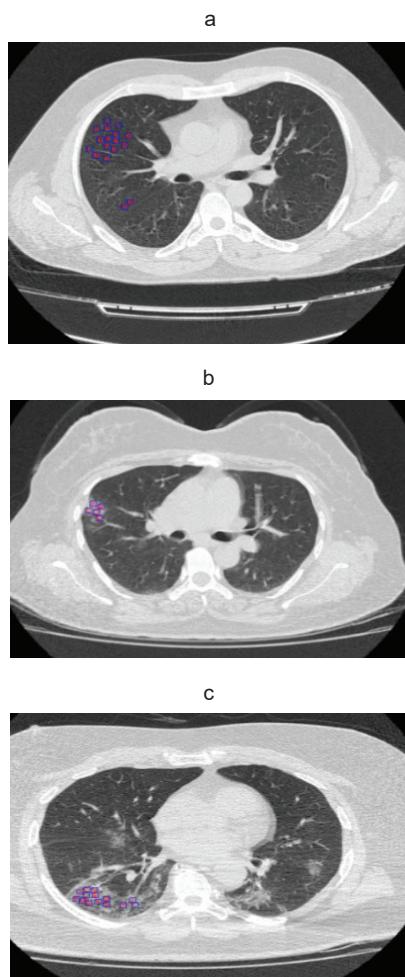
ROI marked on HRCT images of the patients (a) normal (b) mild infected with covid (C) severe with coronavirus disease-2019. In case(c) GGO, consolidation and septal thickening appear that reveals the severity
